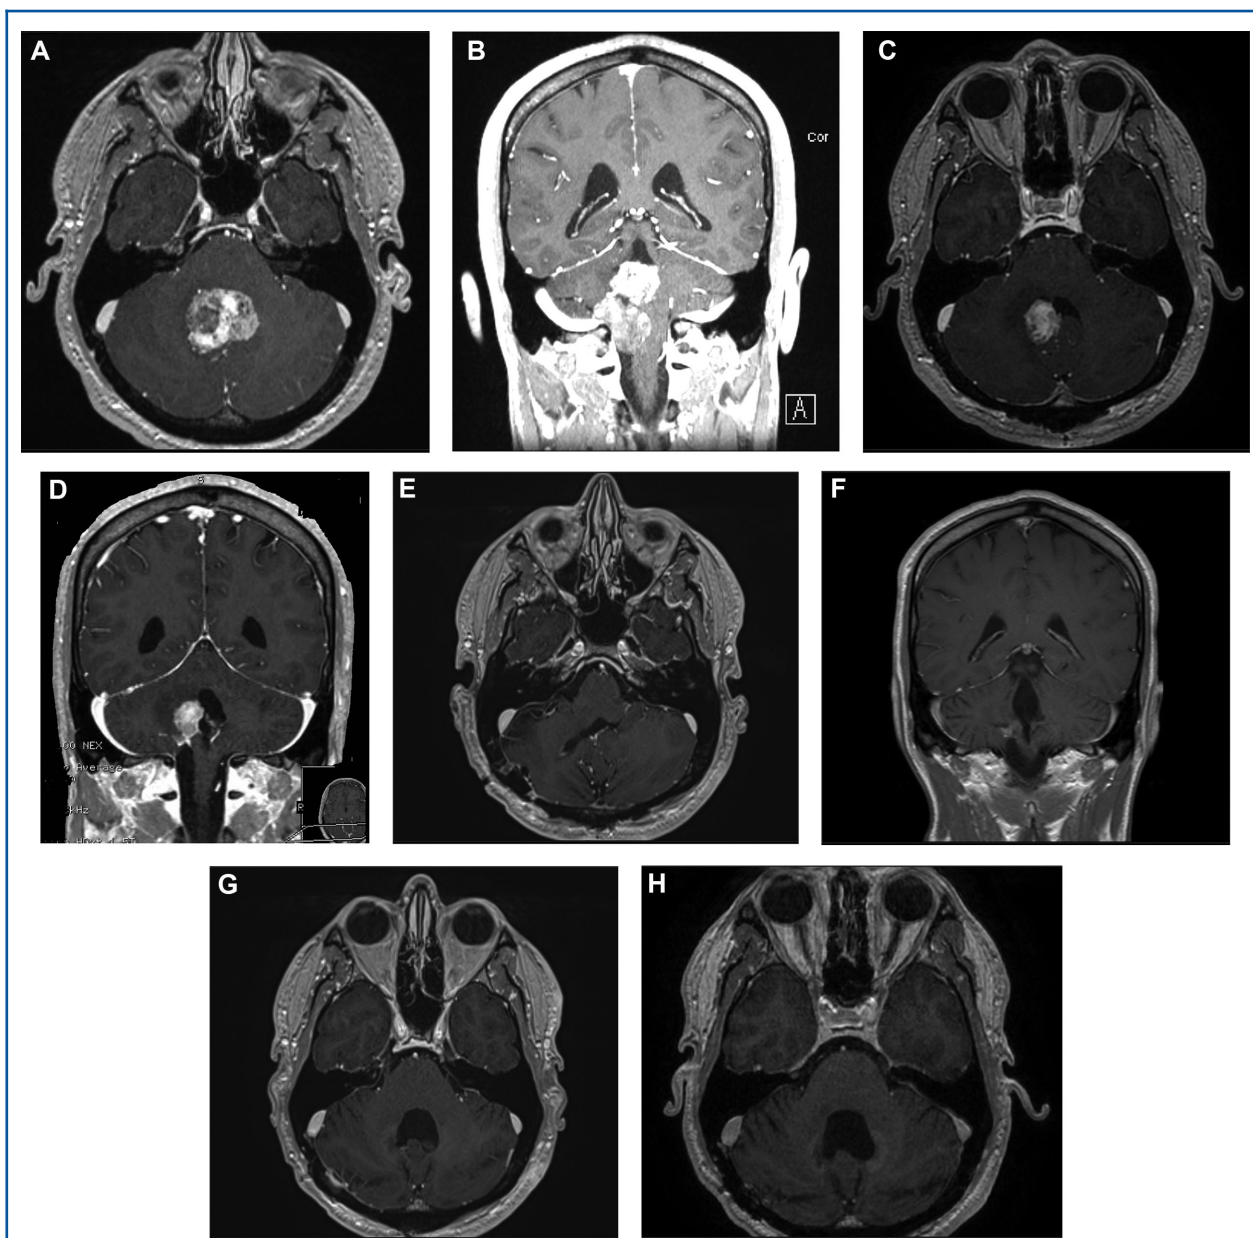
A and B, T1 axial and coronal MR images with contrast before the telovelar approach and before the second stage port procedure. C and D, T1 axial and coronal, contrasted images after initial telovelar approach. E and F, T1 axial and coronal, respectively, MR images with contrast after telovelar approach and the second stage port procedure; E, also shows the majority of the port track through the right cerebellar hemisphere. G, T1 axial MRI with contrast at 6 mo postoperation and H, T1 axial MRI with contrast at 2 yr postoperation, shows no recurrent tumor.
